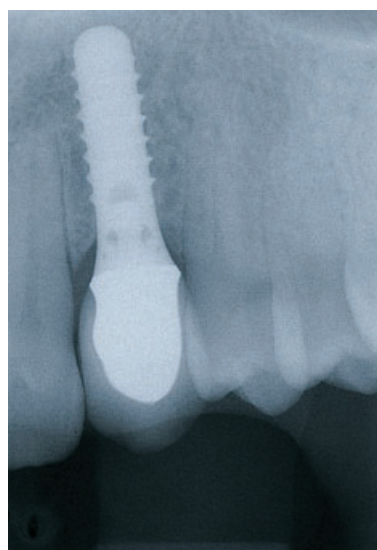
The 2-year follow-up radiograph confirms the stability of the osseointegrated 10 mm solid screw titanium implant.
